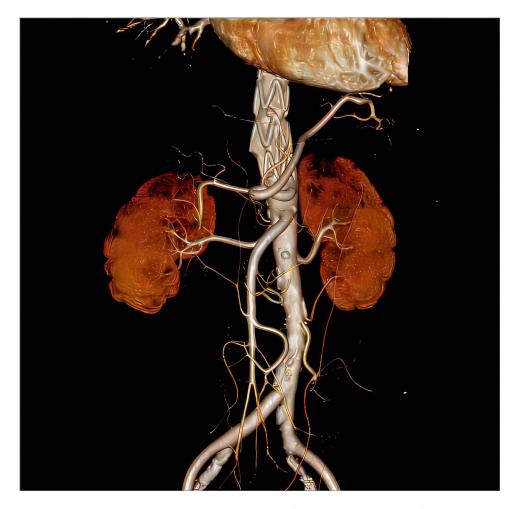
Three-dimensional computed tomography angiography shows the total exclusion of the aneurysm and the absence of endoleaks.
